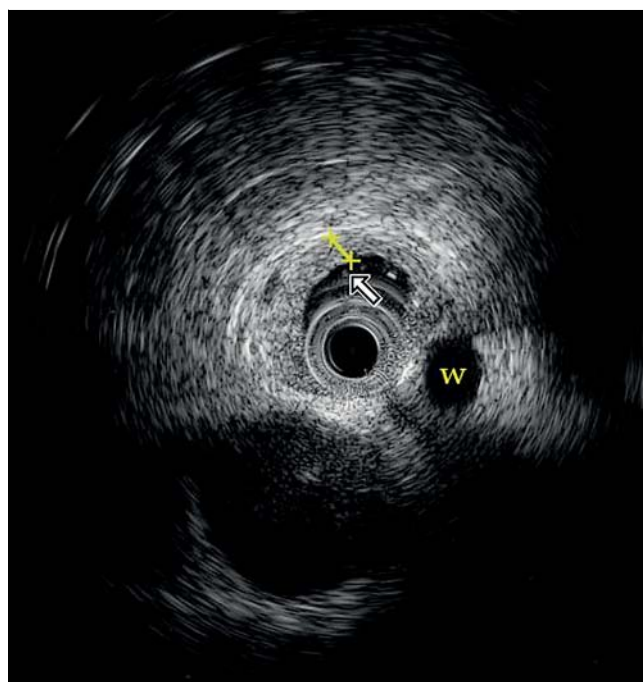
Intraductal ultrasound. The 20-MHz miniprobe shows a diffuse thickening of the common bile duct (arrow) secondary to cholangiocarcinoma (infiltrating type). W, duct of Wirsung.
